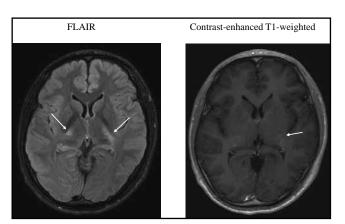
Head MRI of the proband both in contrast-enhanced T1 weighted and in FLAIR (fluid attenuation inversion recovery) method at age of 24. Brain axial FLAIR MR image shows slightly high intensities in bilateral posterior limbs of internal capsules at age of 24 (left panel, arrow). Also, by contrast enhanced T1 weighted MR image at age of 24, the bilateral posterior limbs of the internal capsule (right panel, arrow) is intensified slightly. The gadolinium contrast medium was used at double dose for enhancement. No abnormal signal was detected in white matter of brain.
